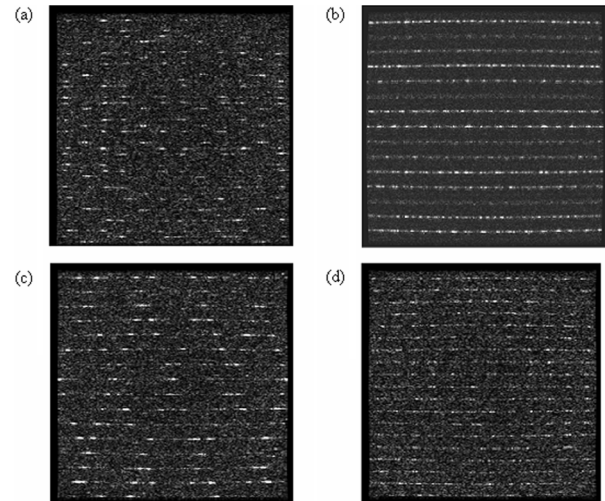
3 T MRI zipper noise pattern with different US transmitting frequencies. (a) 5 MHz, (b) 6 MHz, (c) 7.5 MHz, and (d) 9 MHz.
